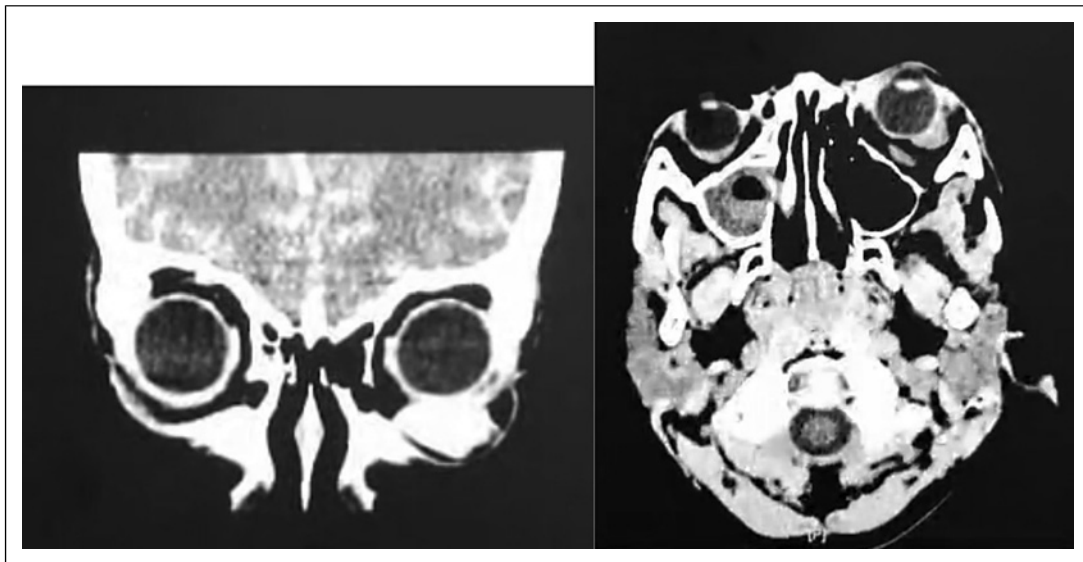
CT-scan result of the patient.
